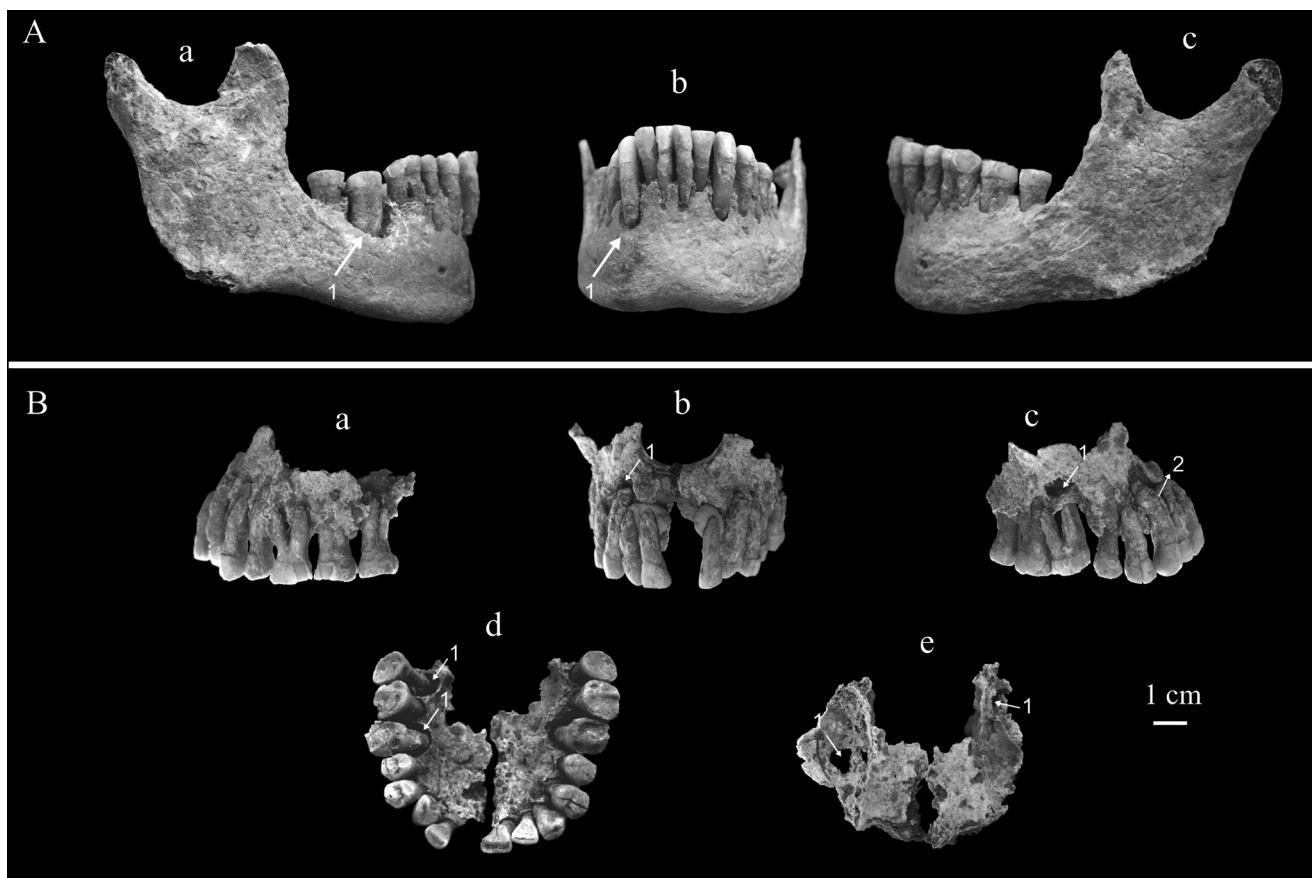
Mandibule et maxillaires de l'individu de la tombe 8 de Kindoki. Les flèches indiquent la localisation des atteintes périapicales (1) et l'hypercémentose (2). A. Mandibule ; a : vue latérale droite ; b : vue antérieure ; c : vue latérale gauche. B. Maxillaires (de la plastiline a été appliquée pour fixer les dents antérieures) ; a : vue latérale gauche ; b : vue antérieure ; c : vue latérale droite ; d : vue inférieure ; e : vue supérieure / Mandible and maxillae of the individual from grave n° 8 at Kindoki. The arrows show the periapical lesions (1) and hypercementosis (2). A. Mandible; a: right side view; b: anterior view; c: left side view. B. Maxillae (plasticine was applied to fix the anterior teeth); a: left side view; b: anterior view; c: right side view; d: inferior view; e: superior view
